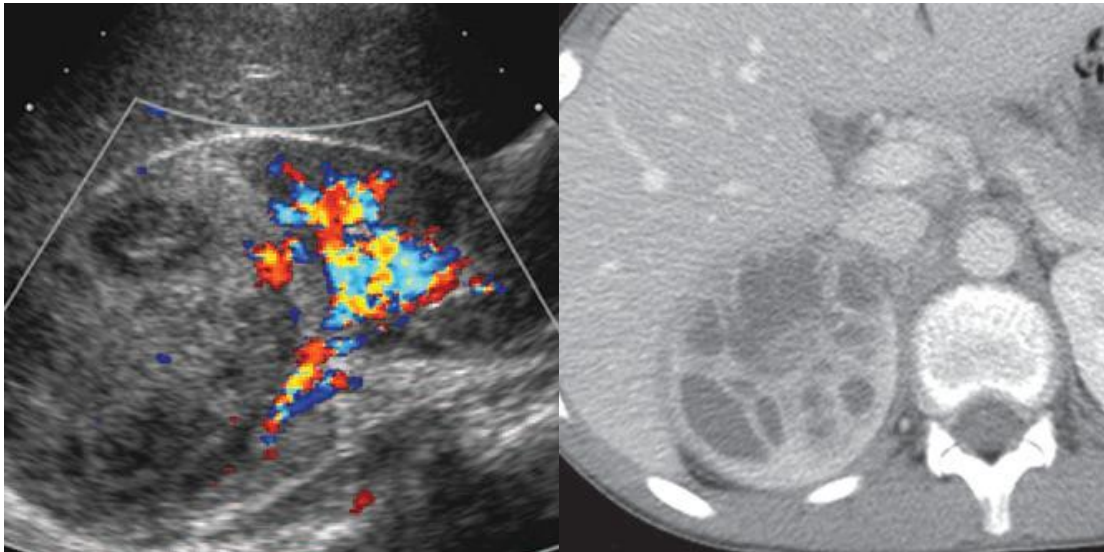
Renal abscess Right: Transverse ultrasound image of right kidney shows avascular heterogeneous area in upper and mid zones. Left: Contrast-enhanced axial CT image shows heterogeneous lesion with multiple internal septations of varying thickness in right kidney
